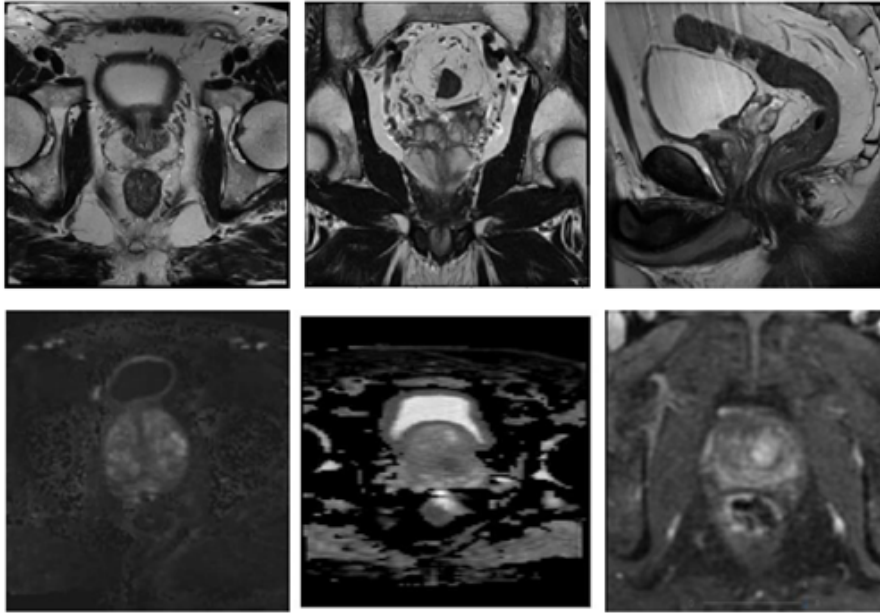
MRI sequences typically included in prostate mp-MRI. Top row: T2W images captured in different planes (from left to right: axial, coronal, and sagittal). Bottom row: DWI with a b-value of 1400, ADC map, and DCE imaging [49].*
